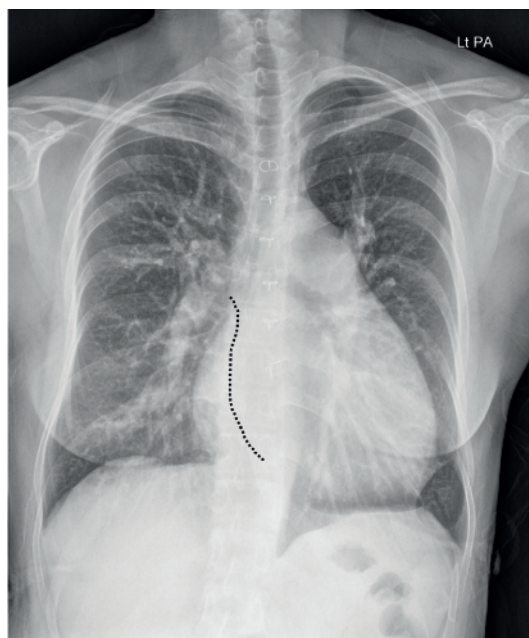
Postero-anterior chest X-ray shows mild cardiomegaly, and an enlarged right atrium with prominent pulmonary vessels. The scimitar vein (dotted line), which is not well detected by visual inspection from this view, courses behind the junction of the superior vena cava and the right atrium before travelling down to the interatrial groove and draining to the right atrium.
